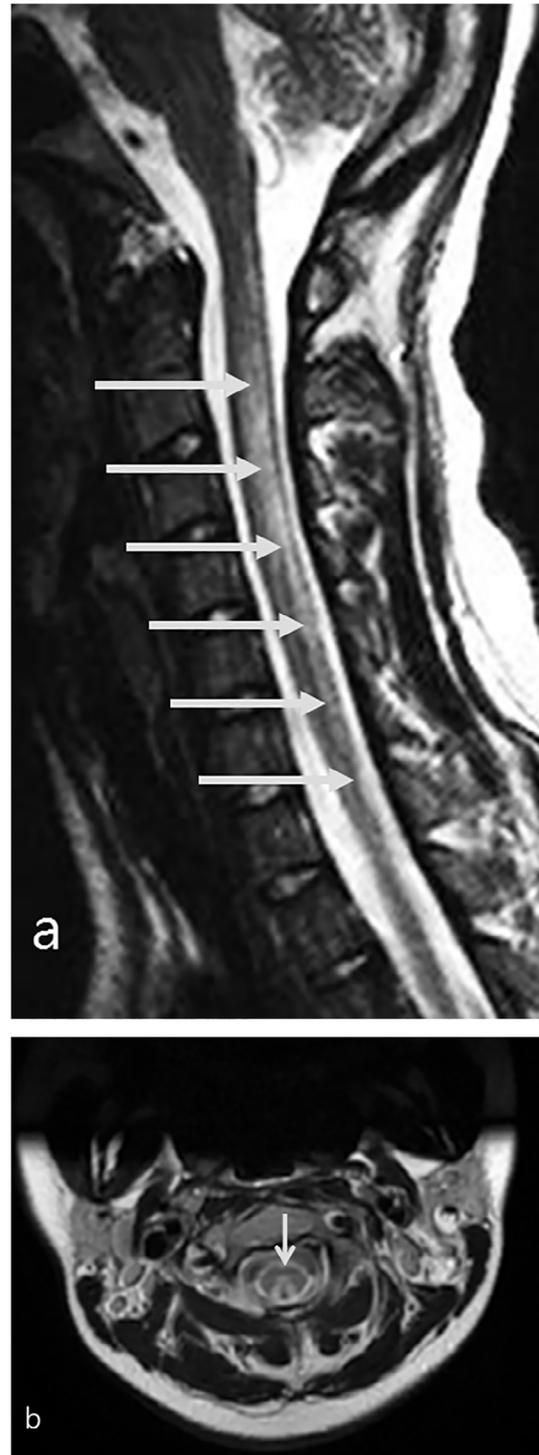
A 15-year-old female suffered from N₂O-induced subacute combined degeneration. Magnetic resonance images of her spinal cord disclosed abnormal hyperintensities within the cervical dorsal column (a). Typical inverted V-shaped T2 signal intensity was noted on axial series (b).
